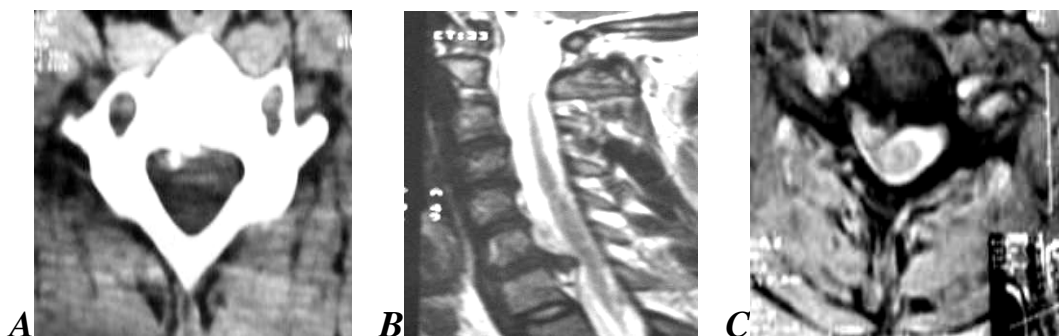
CT axial cut (A) and MRI sagittal (B) and axial (C) cuts at C6-7 level, show disc osteophyte complex compressing the exiting right C-7 nerve root.
